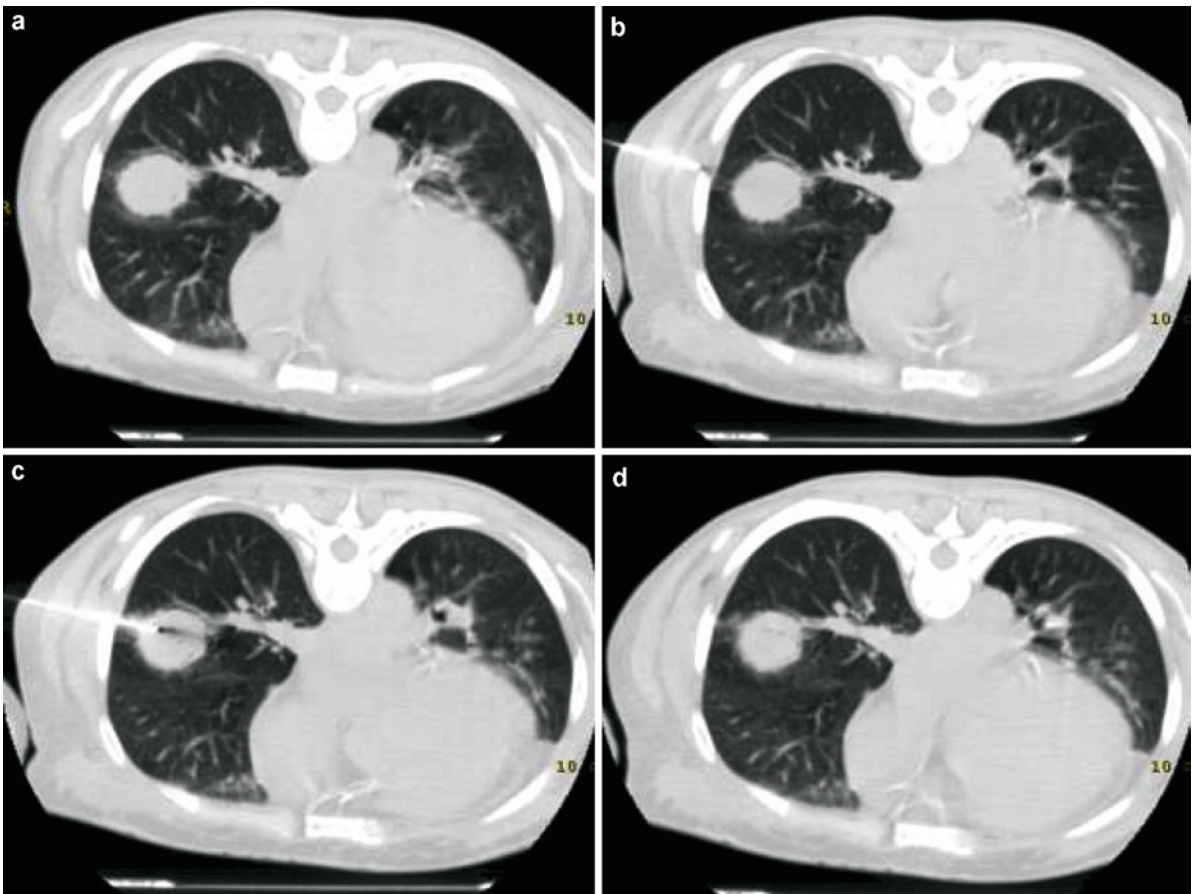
CT-guided lung biopsy in a patient with chronic lymphocytic leukemia who was thought to have aggressive lymphoma. The biopsy diagnosis was pulmonary nocardiosis
